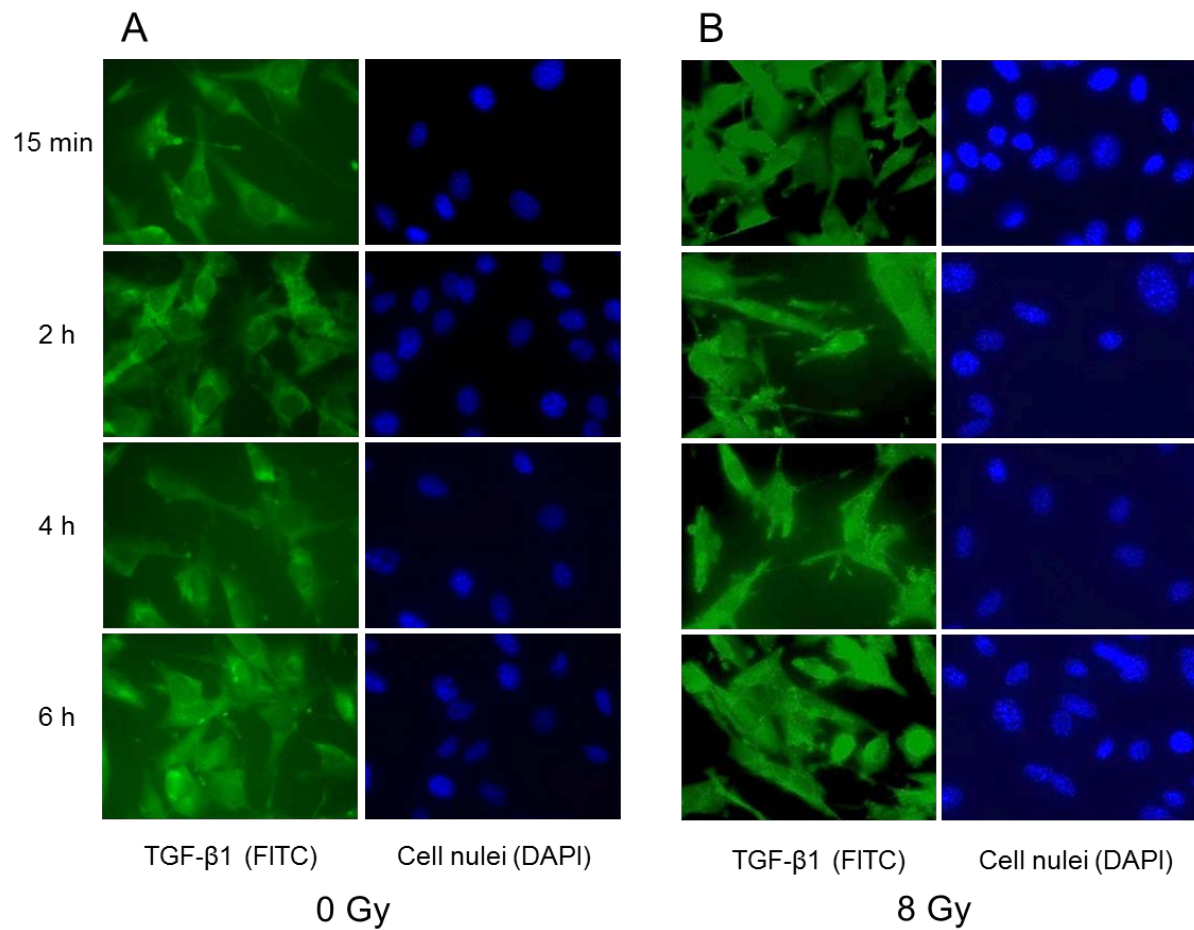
TGF- β 1 expression in OCT-1 cells after X-ray exposure
